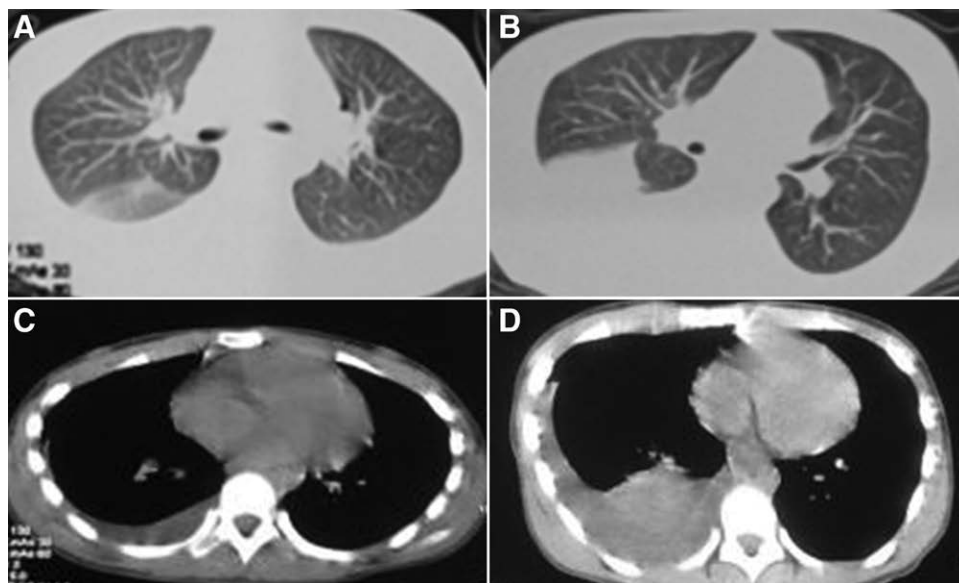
CT image of the child. A: Ground-glass opacities in the right upper lobe on February 5. B: Progressive ground-glass opacities in both lungs on February 19. C: Little pleural effusion on February 5. D: Moderate pleural effusion on February 19.
